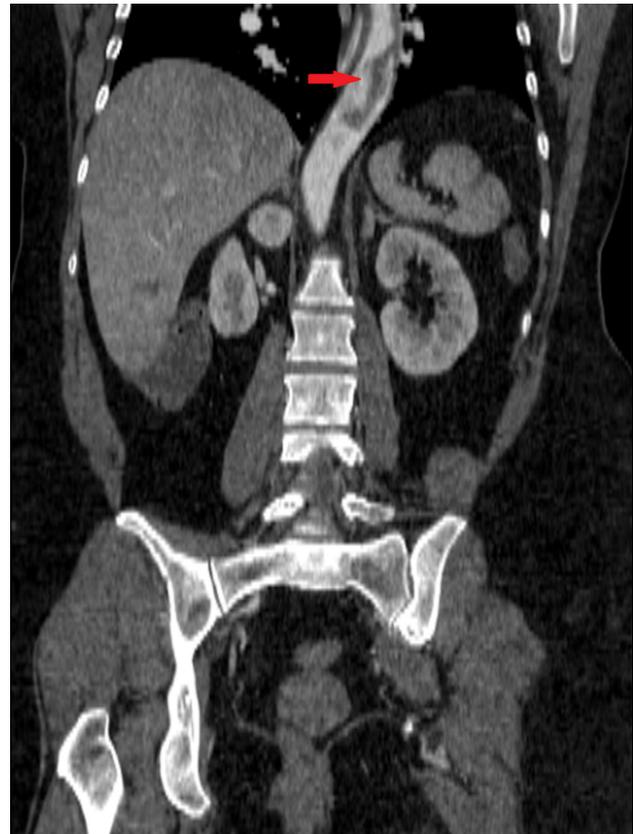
CT angiography, coronal view.
